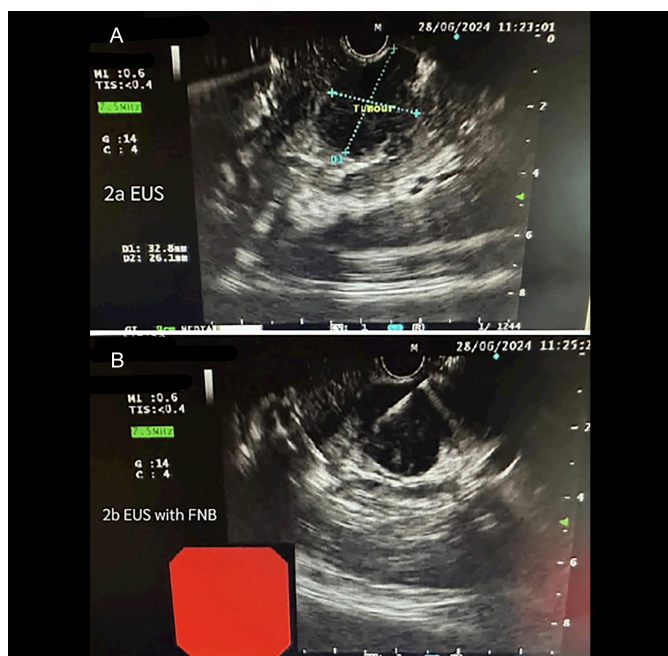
(A) Pancreatic mass on endoscopic ultrasound (EUS). (B) Fine needle aspiration cytology (FNAC) being performed.
